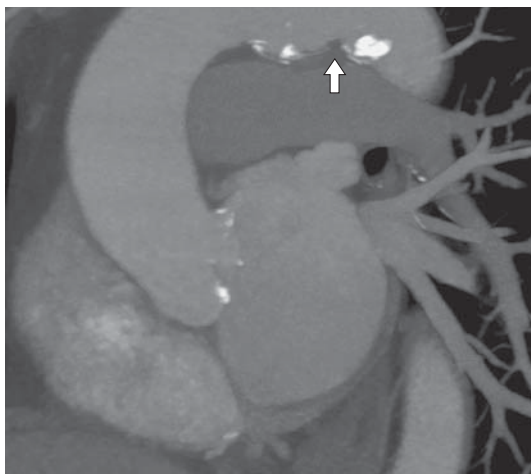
Multispiral CT-aortography shows calcified AV cusps and intimal dissection of the aortic arch.
